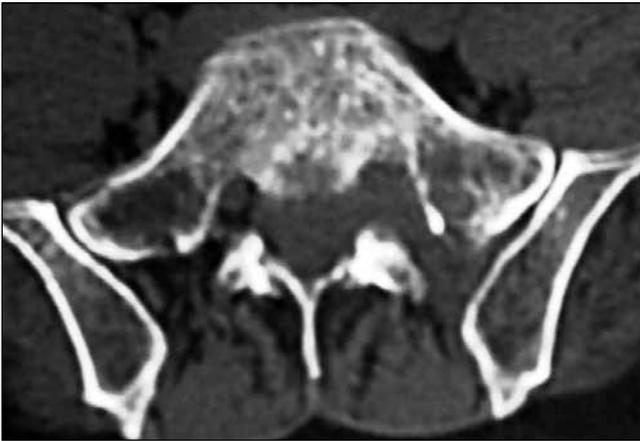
CT scan of lumbosacral spine axial cuts show moth eaten appearance of sacrum.
